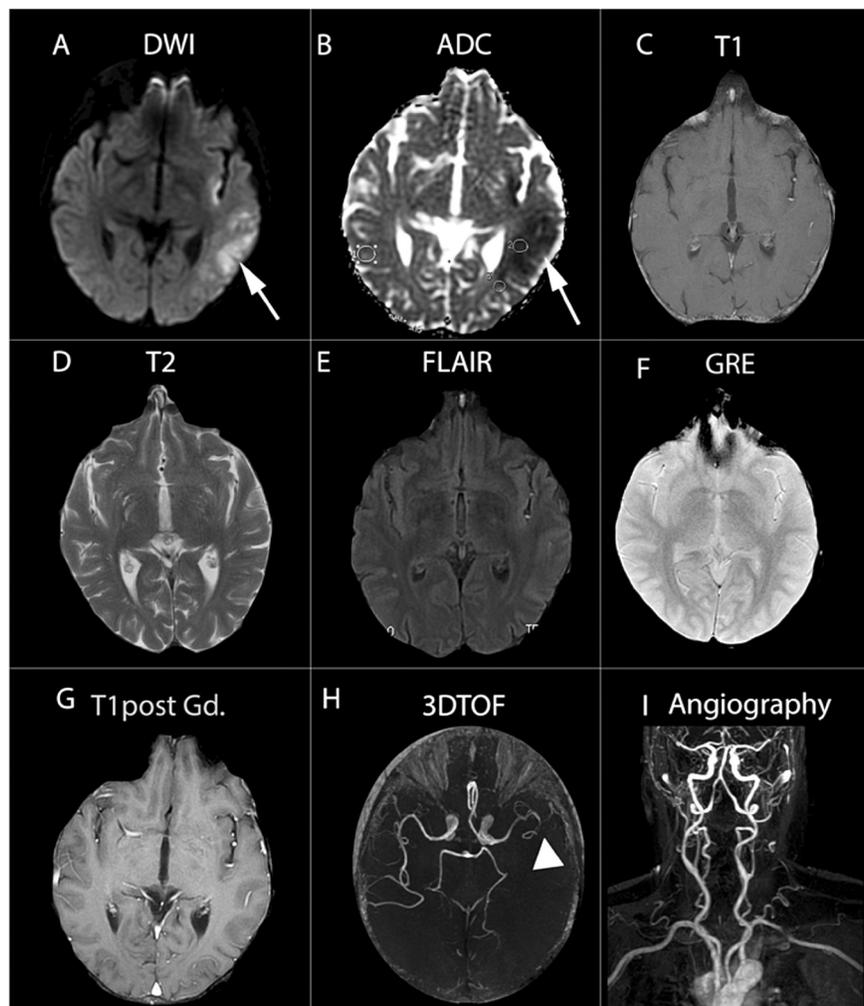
Comprehensive MRI assessment in acute stroke using DWI, PWI and MR angiography. Selected images depict an acute ischaemic infarct (white arrows), which is visible only in A, the diffusion-weighted imaging (DWI); B, the apparent diffusion coefficient map (ADC); and H, the three-dimensional time-of-flight (3D-TOF); in this last sequence, a white arrowhead (image 3H) indicates the occlusion of the M2 segment in the left middle cerebral artery. The rest of sequences in the protocol: C, T1; D, T2 weighted images; E, Flair; F, gradient-echo imaging (GRE); G, T1 post gadolinium administration; and I, carotid-artery MR angiography did not depict conspicuous findings.
